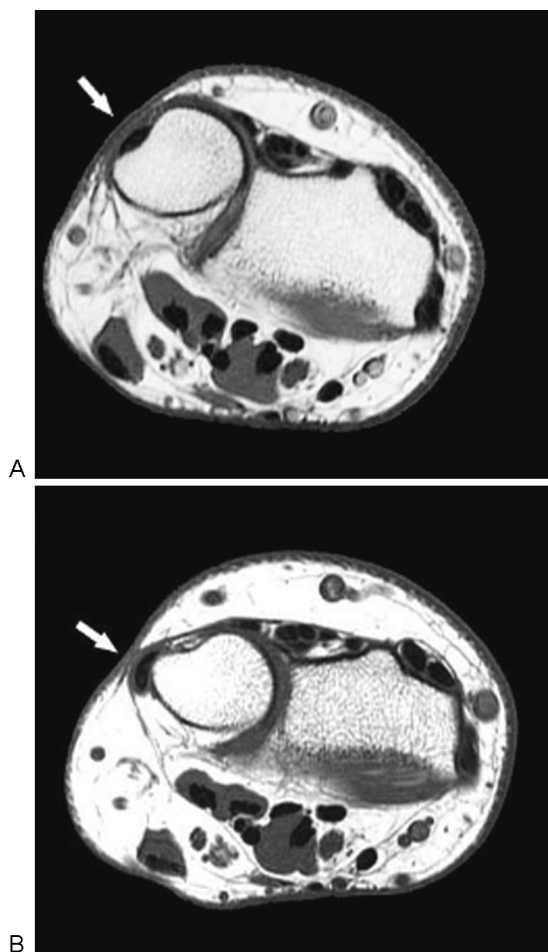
(A) Preoperative and (B) 1-year postoperative left wrist axial T1 weighted magnetic resonance imaging views demonstrating a dislocated extensor carpi ulnaris tendon out of the ulnar groove postoperatively.
